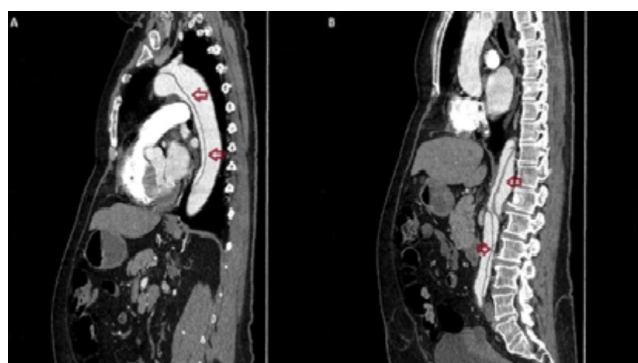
CT images present Stanford type B aortic dissection (AD), beginning at the arch level (A) and ending at the external iliac arteries (B).
